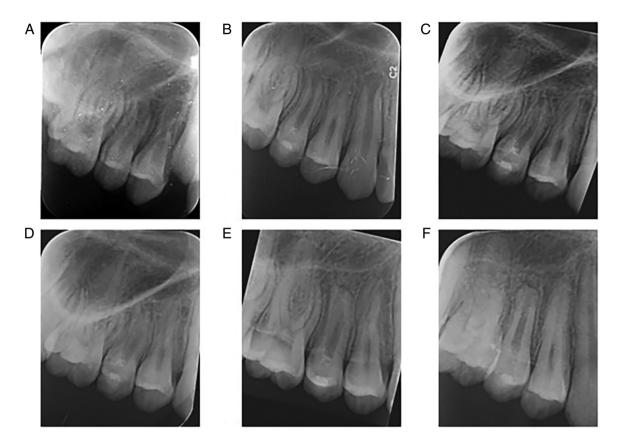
Follow-up periapical radiographs of tooth #15. (A) Preoperative radiograph. (B-F) follow-up radiograph after REPs at (B) 1 year, (C) 2 years, (D) 3 years, (E) 4 years and (F) 5 years. REPs, regenerative endodontic procedures.
